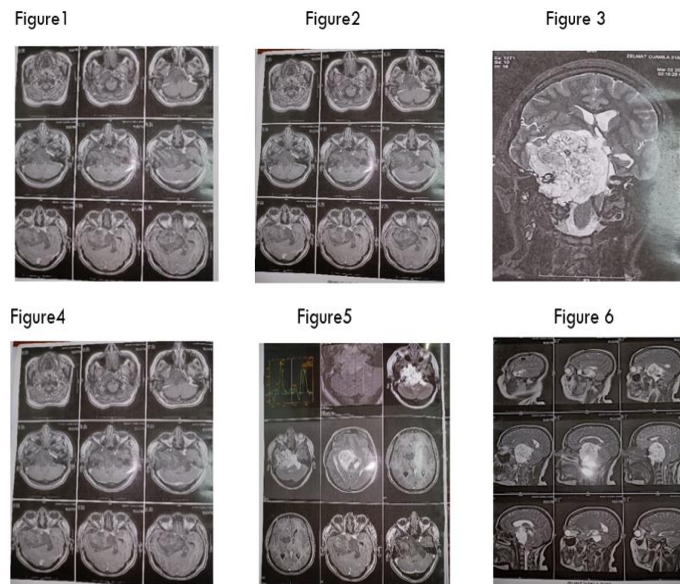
Magnetic Resonance Imaging Results Showing Height, The Location and Extension Of The Chordom
